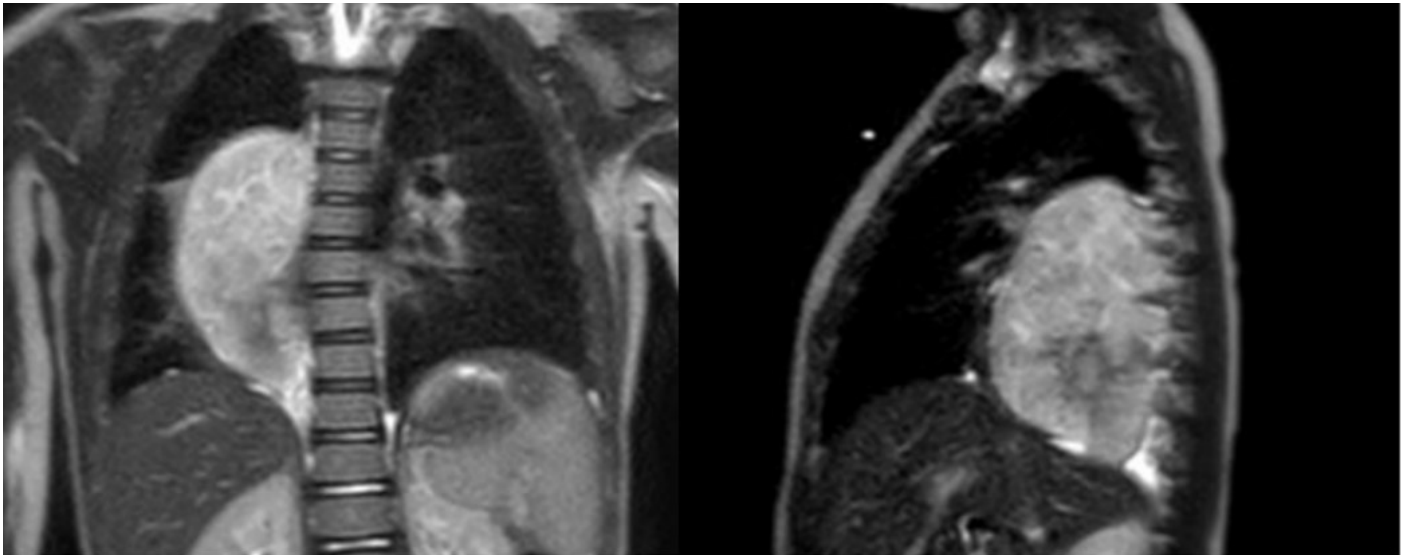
Contrast-enhanced chest MRI in coronal (A) and sagittal (B) reconstructions, demonstrating a mass lesion in the mid-posterior mediastinum (6.0 × 3.9 × 3.8 cm), of heterogeneous texture, with discrete heterogeneous contrast enhancement. The lesion is closely related to the large mediastinal vessels, right main bronchus, vertebral bodies, right atrium, diaphragm, and esophagus. There are no direct signs of invasion of these structures.
